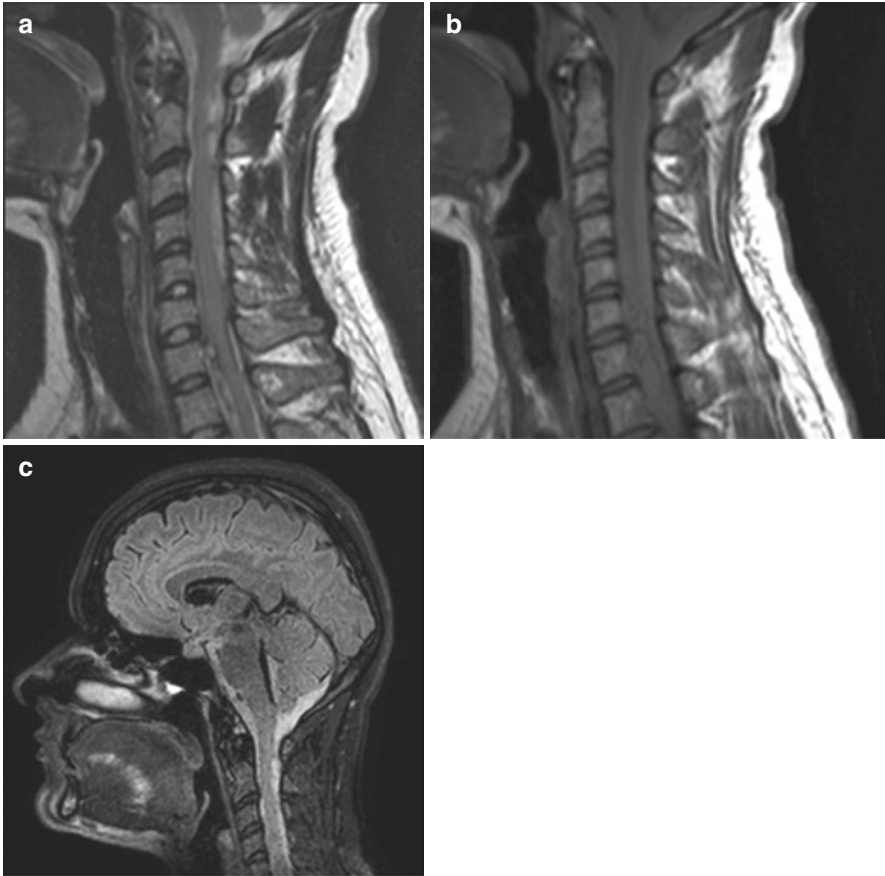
(a) On T2W images, a dorsally located hyperintense collection was detected. (b) On T1W images, the signal of the entire subdural space (both anterior and posterior to spinal cord) has increased due to subdural hematoma, and the bleeding is observed down to the T10 level. (c) On FLAIR images, the signal of the entire subdural space has increased from the clivus and cisterna magna down to the T10 level
